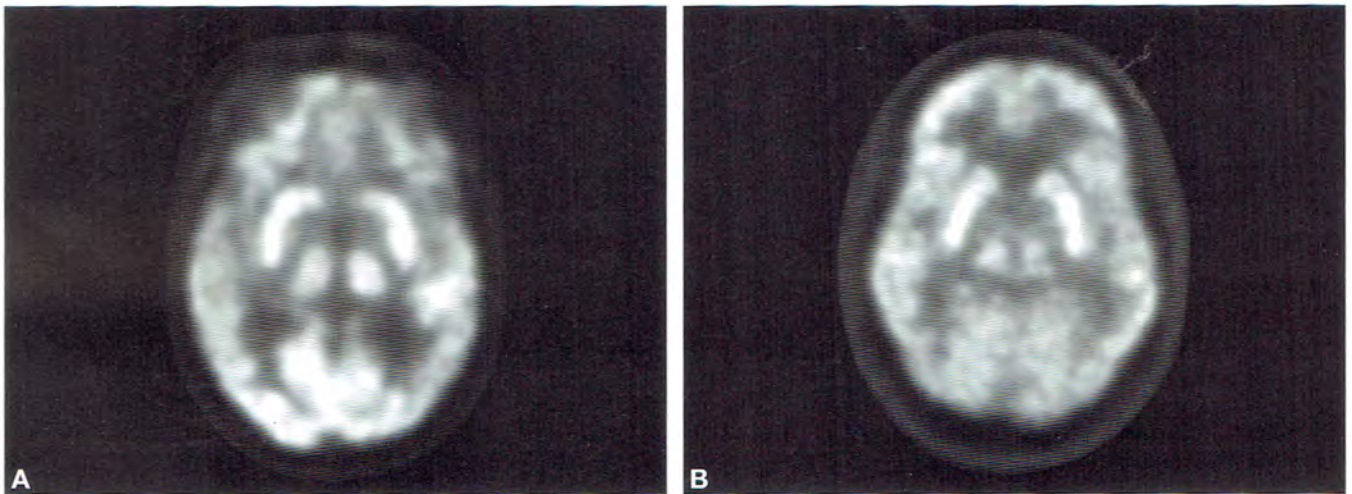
Significantly decreased FDG activity is seen in the bilateral temporal lobes of the first image. The second image represents a normal brain for comparison.
